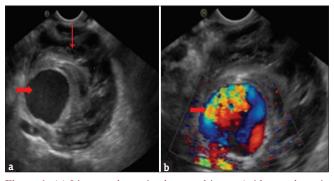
(a) Linear endoscopic ultrasound image (with transducer in stomach) showing outer hypoechoic and central anechoic area and (b) color Doppler image showing vascular flow in anechoic area. Response: part labelled. Response: (a) Linear endoscopic ultrasound image (with transducer in stomach) showing outer hypoechoic (plain arrow) and central anechoic area (block arrow) and (b) color Doppler image showing vascular flow in anechoic area (block arrow)
